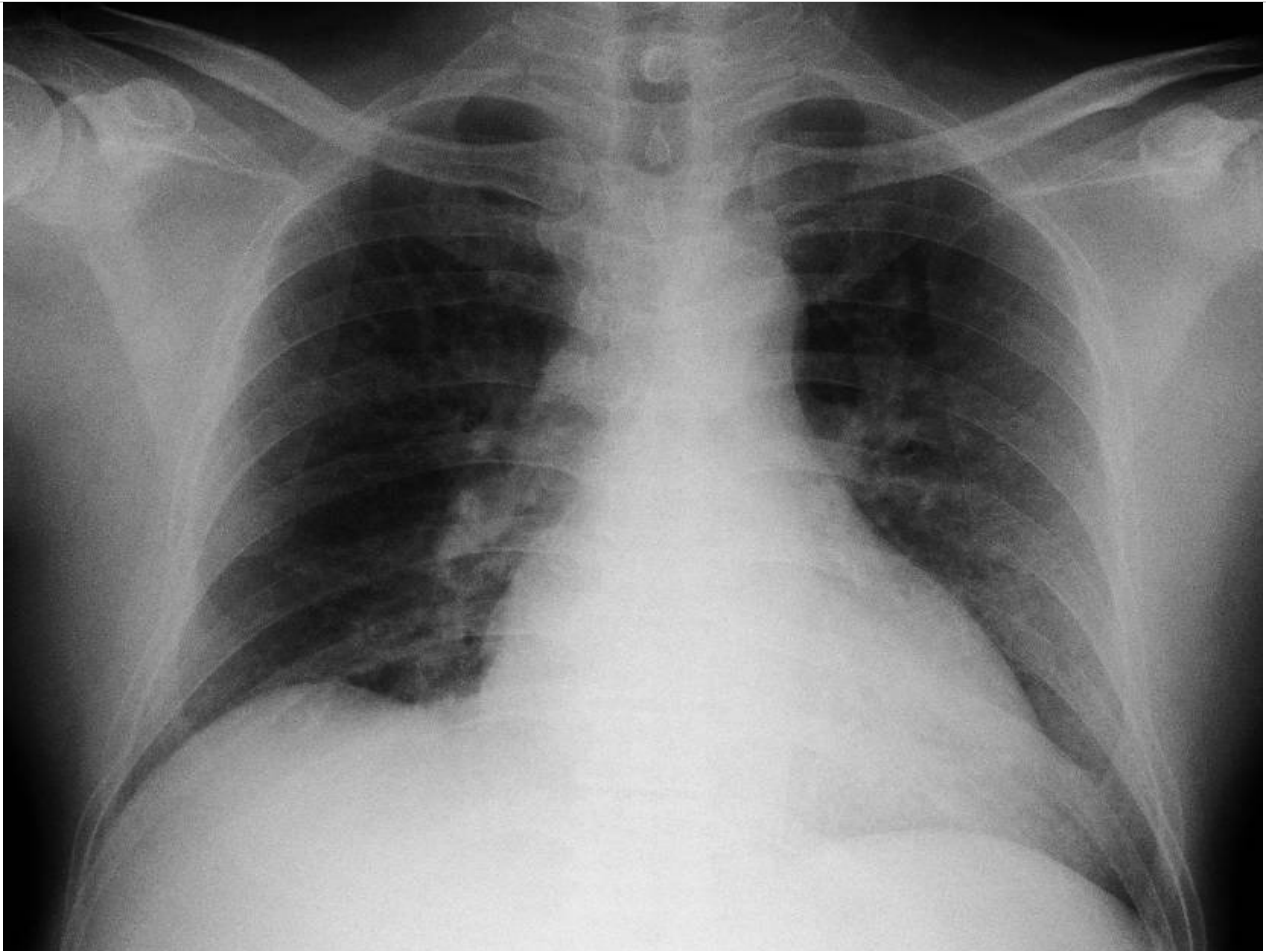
Chest X-Ray result of patient in Case 1. Chest X-Ray was within normal limit, no sign of pneumonia was found.
